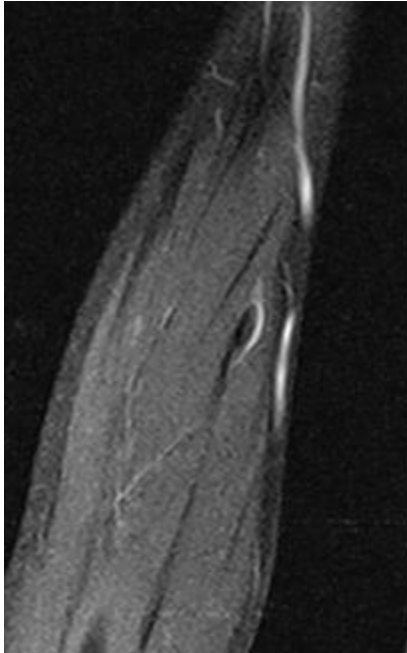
MRI showing a well-circumscribed oval lesion in the radius.
